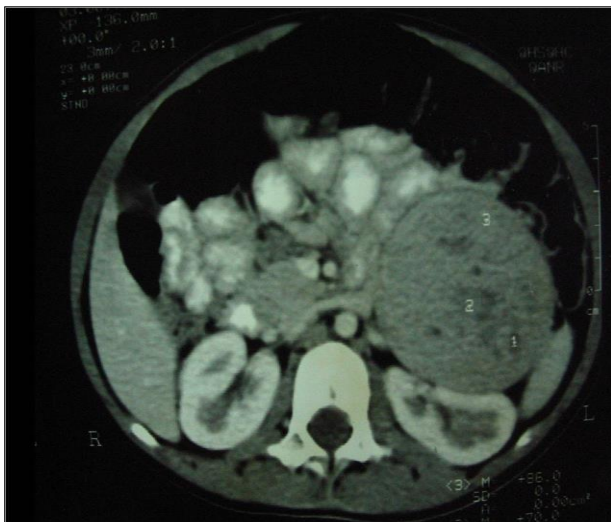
CT abdomen showing mass arising from left adrenal gland.
